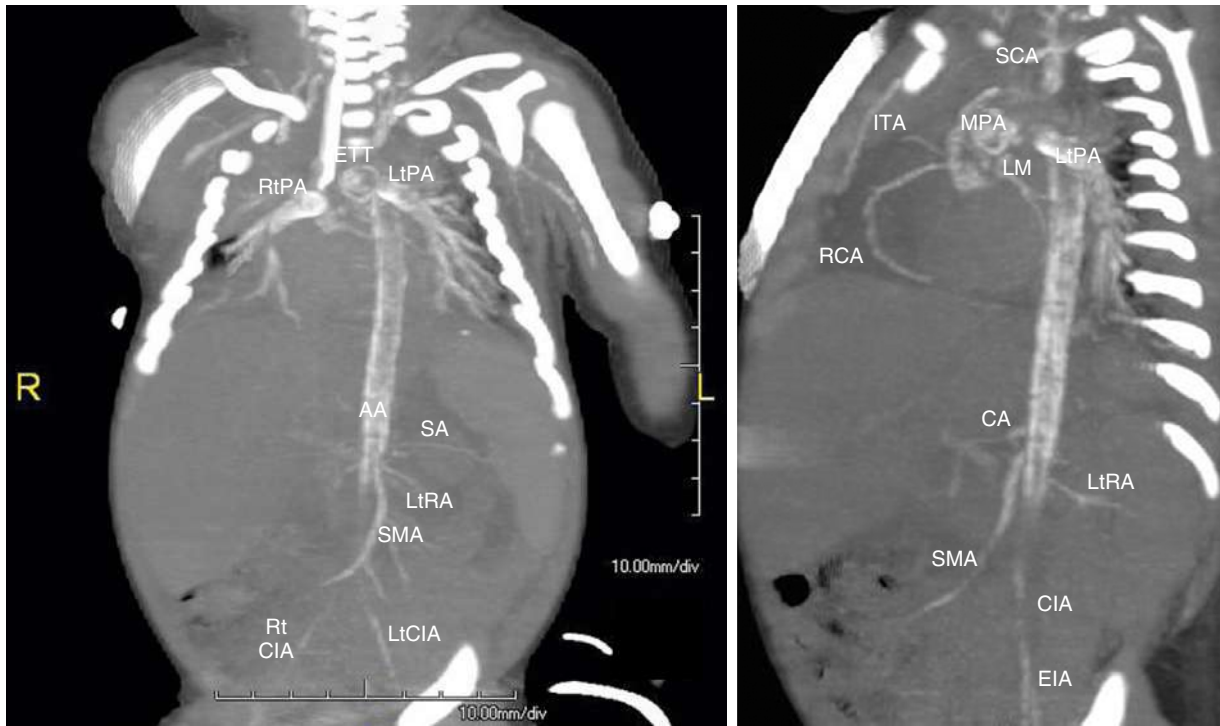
Coronal maximum intensity projection (MIP) CT scans demonstrate an endotracheal tube (ETT) and extensive vascular calcifications. PA, Pulmonary artery; SA, splenic artery; RA, renal artery; CIA, common iliac artery; BA, brachial artery; CA, celiac axis; SMA, superior mesenteric artery; SCA, subclavian artery. (From Bolster F, Ali Z, Southall P, et al. Generalized arterial calcification of infancy—findings at post-mortem computed tomography and autopsy. *Forensic Sci Int.* 2015;254:e7–e12, Fig 3.)
